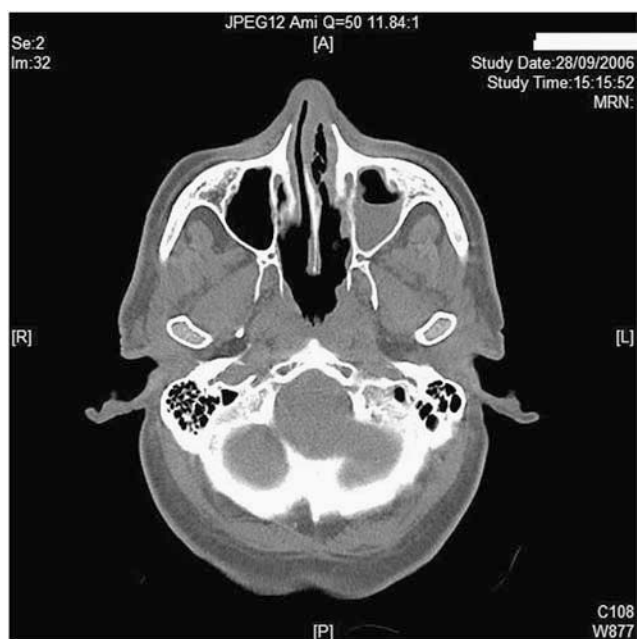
CT scan showing partial occupation of the left maxillary sinus.
